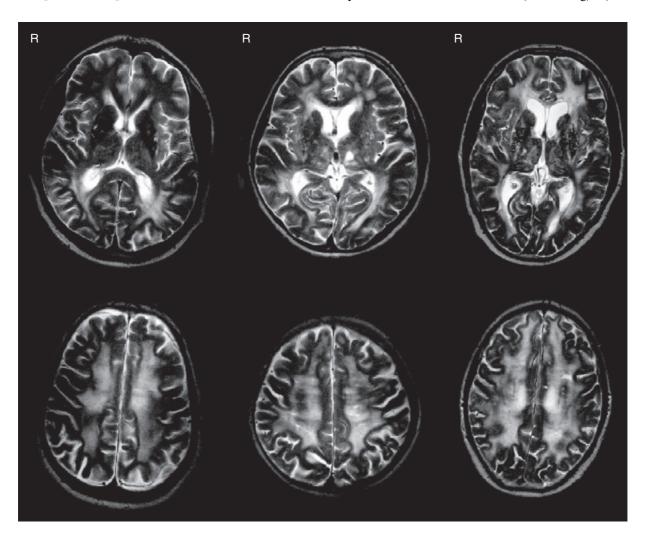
Comparison of T2-weighted MR-images of patient I (left), patient II (middle), and patient III (right). Upper row: axial images at the level of the basal ganglia. Lower row: axial images at the level of the centrum semiovale. Confluent white matter lesions (WMLs) as well as lacunar infarcts are most pronounced in patient III. Note the marked involvement of the frontal white matter and the extension of the WMLs into the subcortical U-fibers in this patient.
